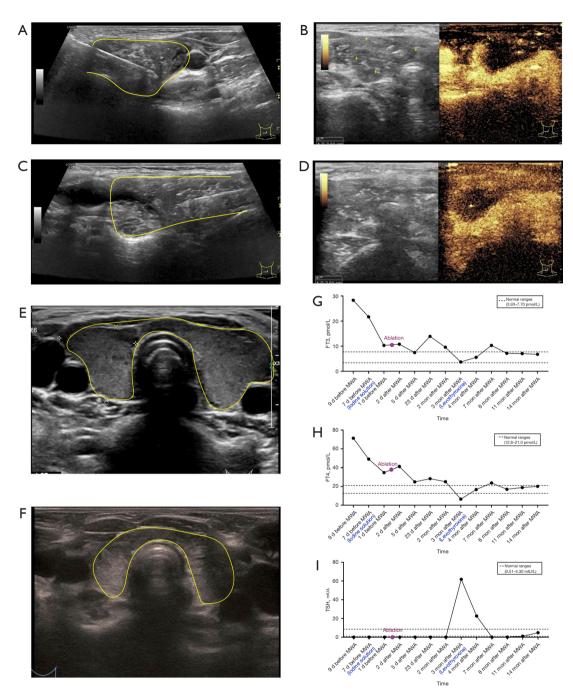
The ultrasound images during ablation, contrast-enhanced ultrasound, and the changes in thyroid size and function before and after microwave ablation for the second patient. (A) Left lobe during ablation. (B) Contrast-enhanced ultrasound evaluating the extent of left lobe ablation. (C) Right lobe during ablation. (D) Contrast-enhanced ultrasound evaluating the extent of right lobe ablation. (E) Preoperative thyroid transverse ultrasound image. (F) Thyroid transverse ultrasound image 9 months postoperation. (G) Changes in FT3. (H) Changes in FT4. (I) Changes in TSH. FT3, free triiodothyronine 3; FT4, free thyroxine 4; TSH, thyroid-stimulating hormone.
